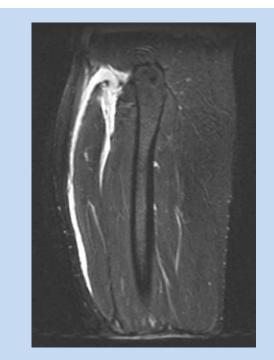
Sagittal fast-spin echo inversion recovery T2-weighted image of right thigh performed approximately 6 hours after injury.
